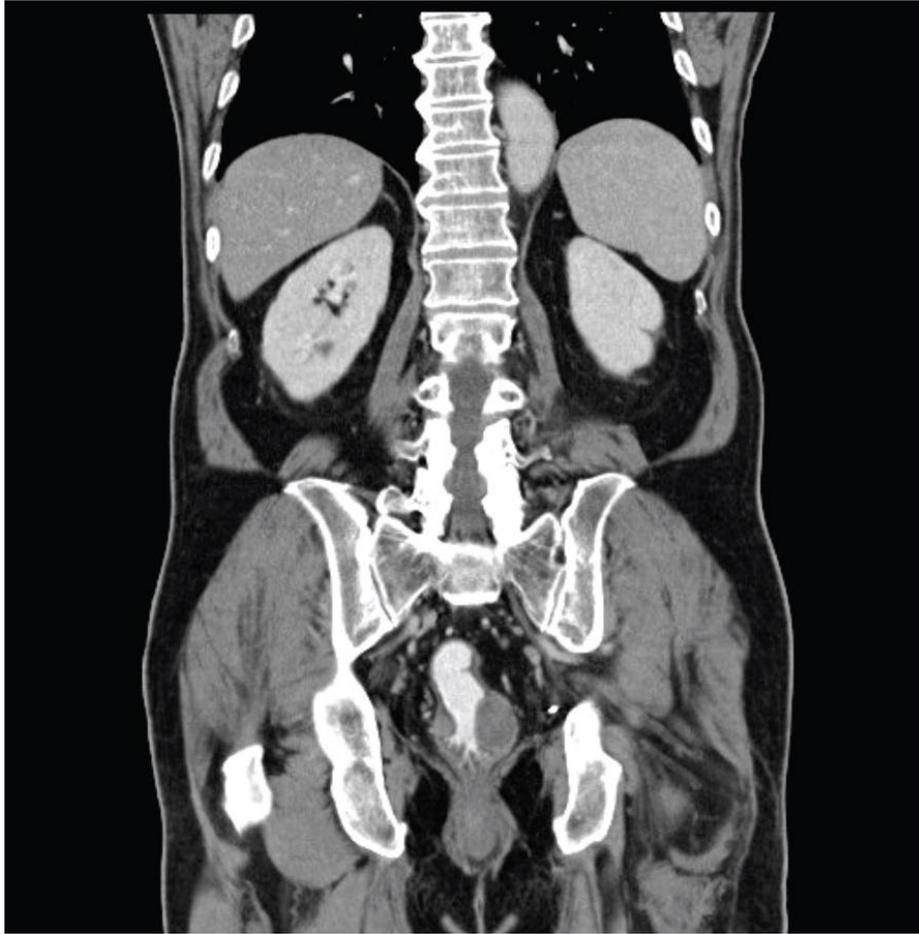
Post-operative CT scan showing rectal thickening of 2.5cm. There is no lymphadenopathy or distant metastases.
